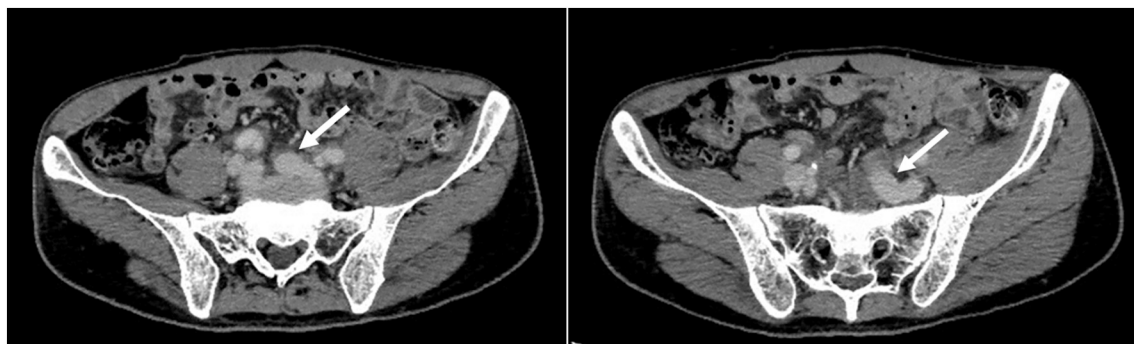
Contrast-enhanced CT images obtained 2 days after injury show a reduction in hematoma around the left common iliac vein, with no evidence of venous thrombosis or stenosis (*arrow*).
